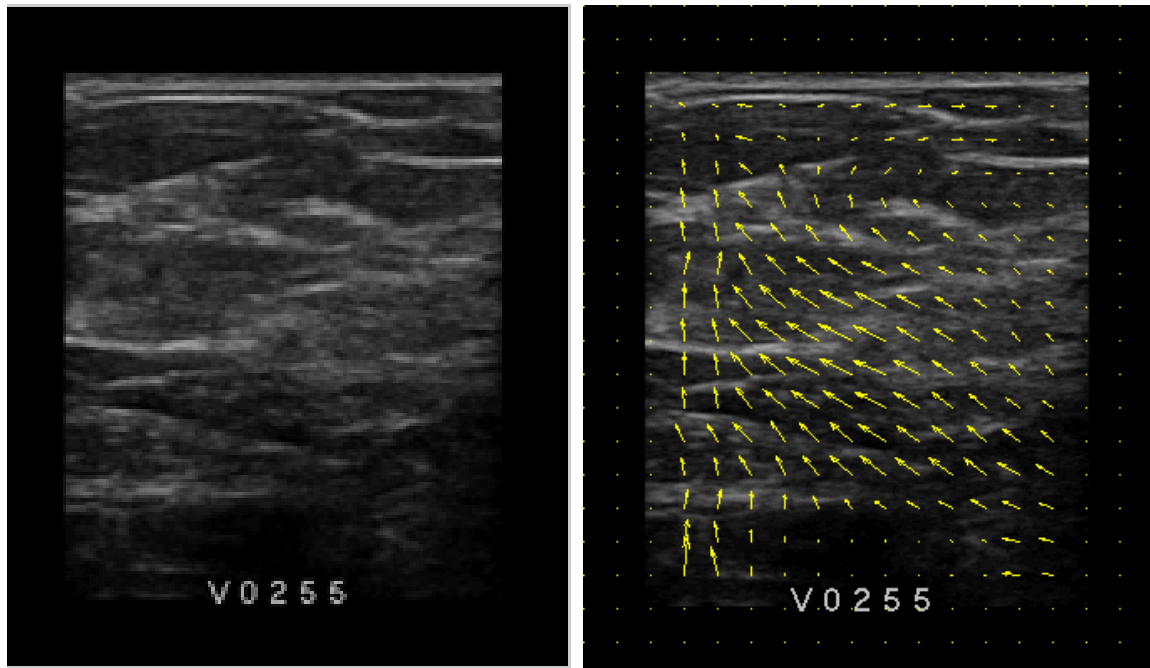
Ultrasound image along with optical flow displacements with another image
